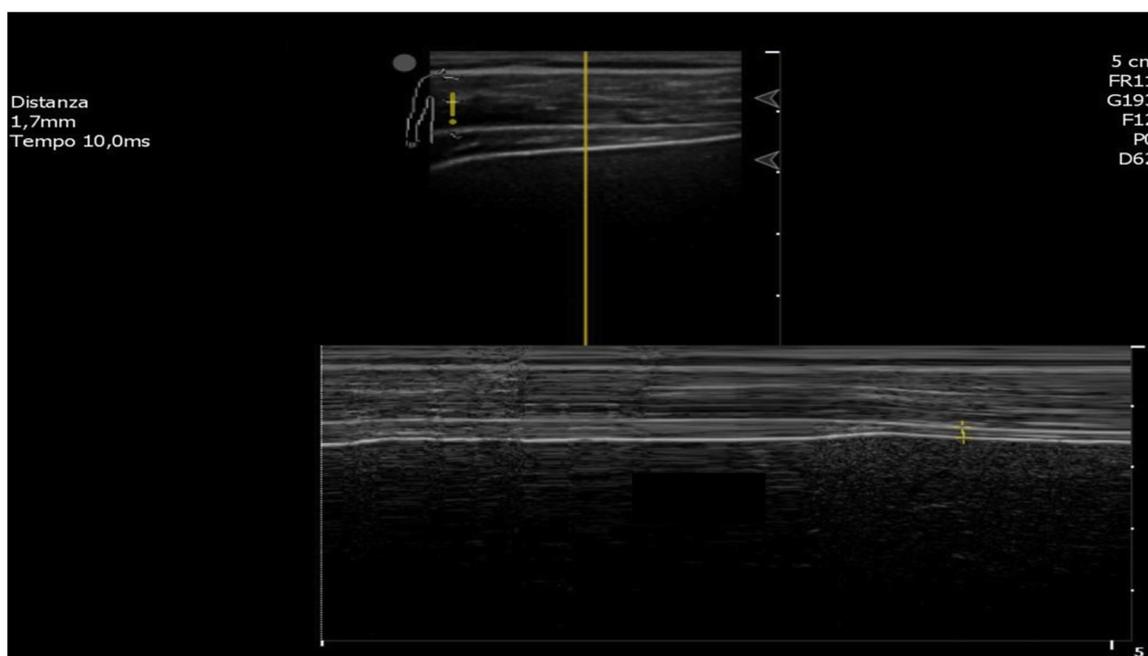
B-mode (upper panel) and M-mode (lower panel) ultrasound view of the diaphragm.
